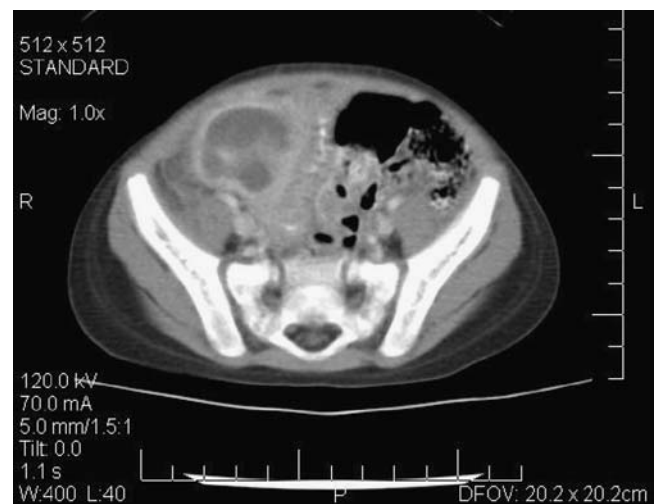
CT scan of perforated appendix with abscess.
